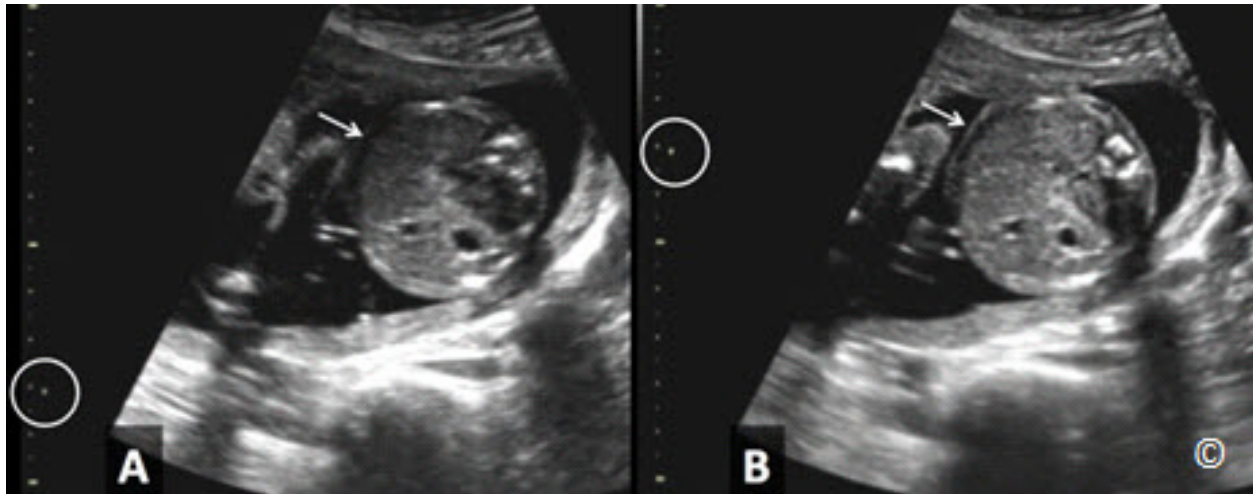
A and B: Ultrasound of the transverse plane of the fetal abdomen. In A, the focal zone is erroneously applied below the target organ (circle). Note the improved lateral resolution (arrows – compare A to B) of the target organ (abdomen) in B where the focal zone is accurately applied (circle).
